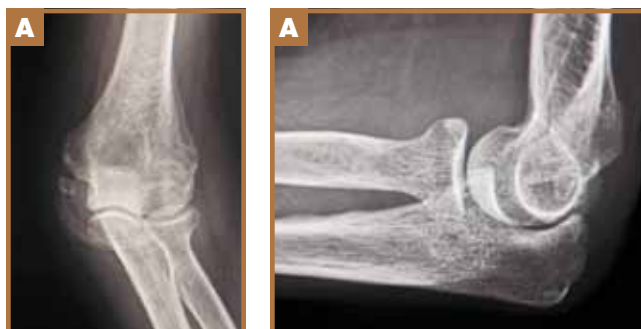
Follow-up anteroposterior (A) and lateral (B) radiographs showing the elbow is concentrically reduced.
